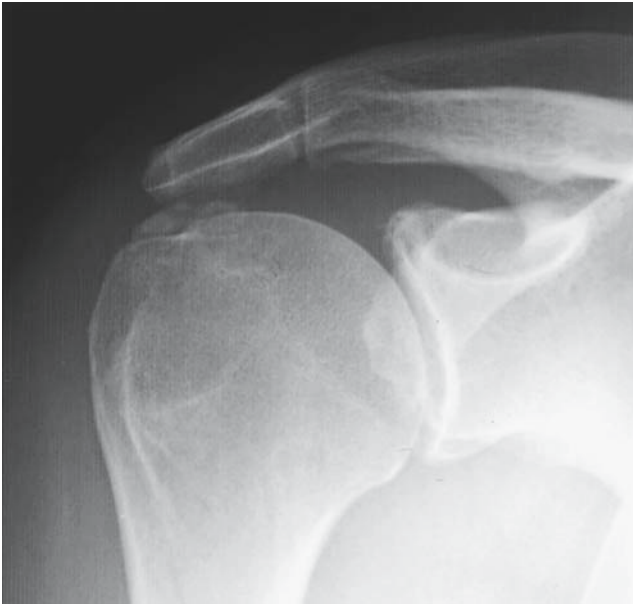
A calcium deposit is present in the supraspinatus tendon immediately medial to its attachment site on the greater tuberosity in this true AP X-ray of the glenohumeral joint.
